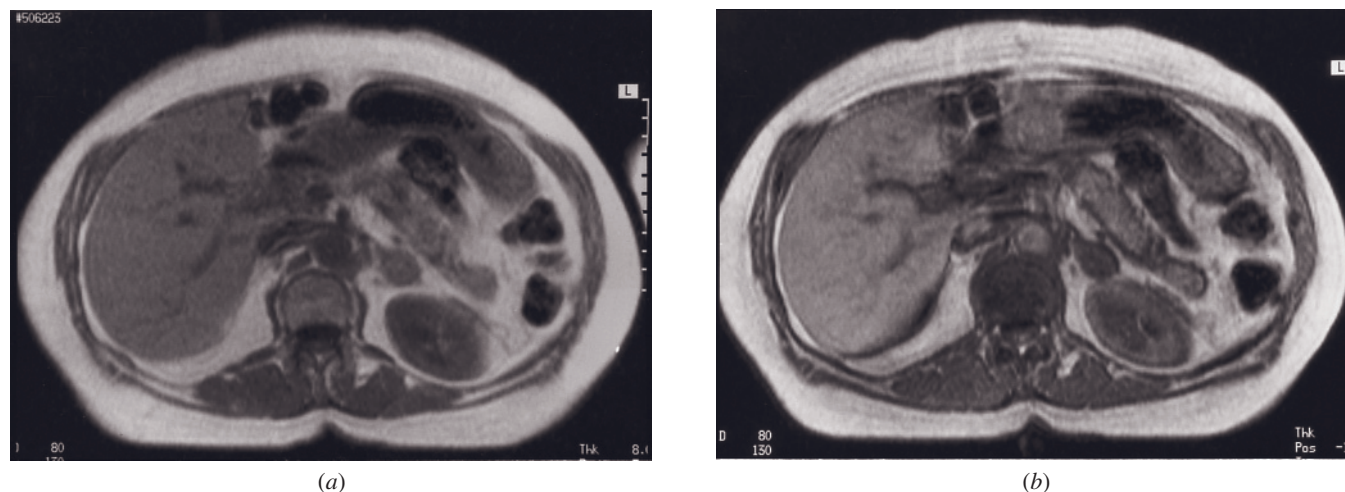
Adrenal adenoma—mild signal drop. T1-weighted GE (a) and T1-weighted out-of-phase GE (b) images. Mild signal intensity loss (approximately 15%) is noted from in-phase (a) to out-of-phase (b) images, which is in the low range for signal intensity drop to diagnose an adrenal mass as an adenoma. The extent of signal intensity drop is consistent with minimal intracytoplasmic lipid.
